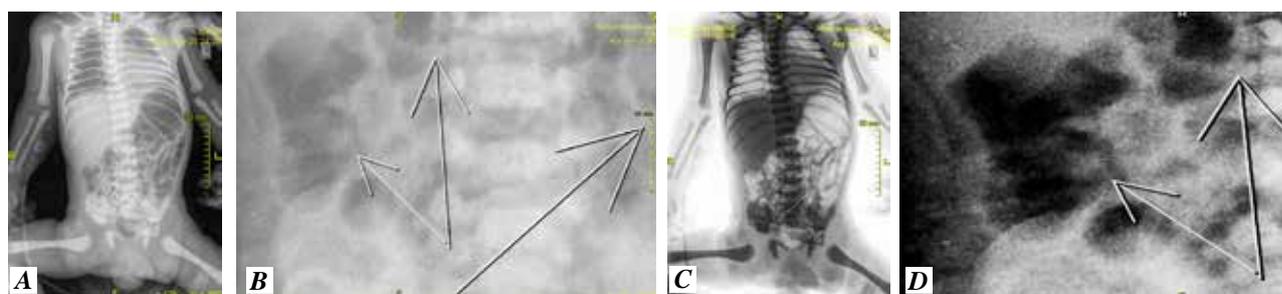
All X-ray images were processed by a digital program, with measurements of intestinal wall pneumatosis
